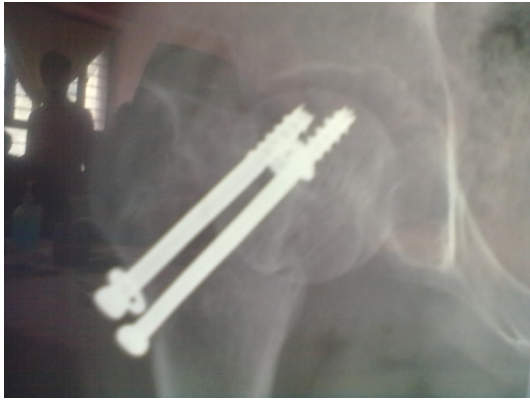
case 2: Postoperative x-ray at 16 weeks
